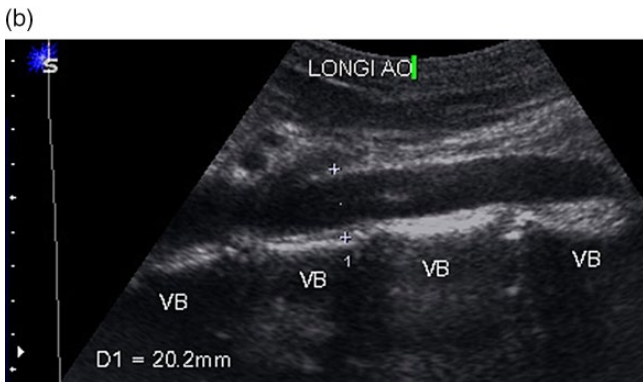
Aorta shown in the longitudinal plane. The aorta (Ao) lies immediately anterior to the vertebral bodies (VB). Arrowheads indicate the body of the pancreas overlying the superior mesenteric vein (SM). In many patients, the liver (Li) does not provide such a good sonographic window. SMA, superior mesenteric artery, SMV superior mesenteric vein.
